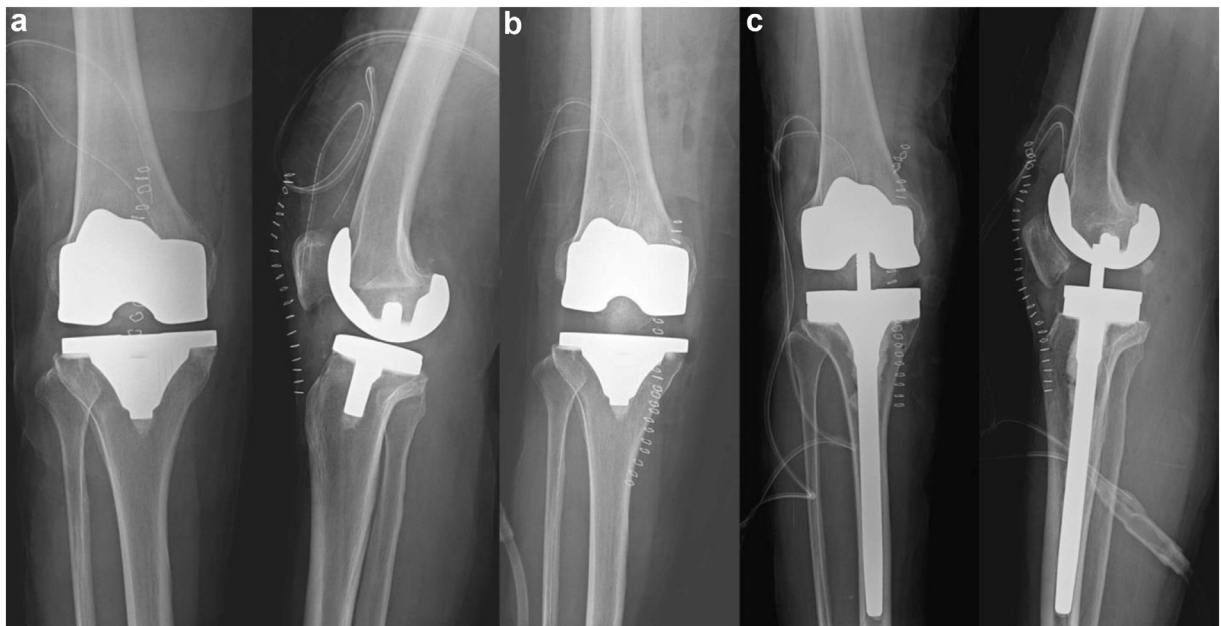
(a) Patient 3. A 67-year-old female underwent right TKA with a 10-mm tibial insert. A lateral radiograph shows a femoral component flexion angle of 7.0° and a posterior tibial slope of 8.0° . (b) She underwent isolated tibial insert exchange with an 18-mm tibial insert following a tibial post fracture. (c) Postoperative radiographs show tibial revision surgery with TS tibial insert after a tibial post refracture.
